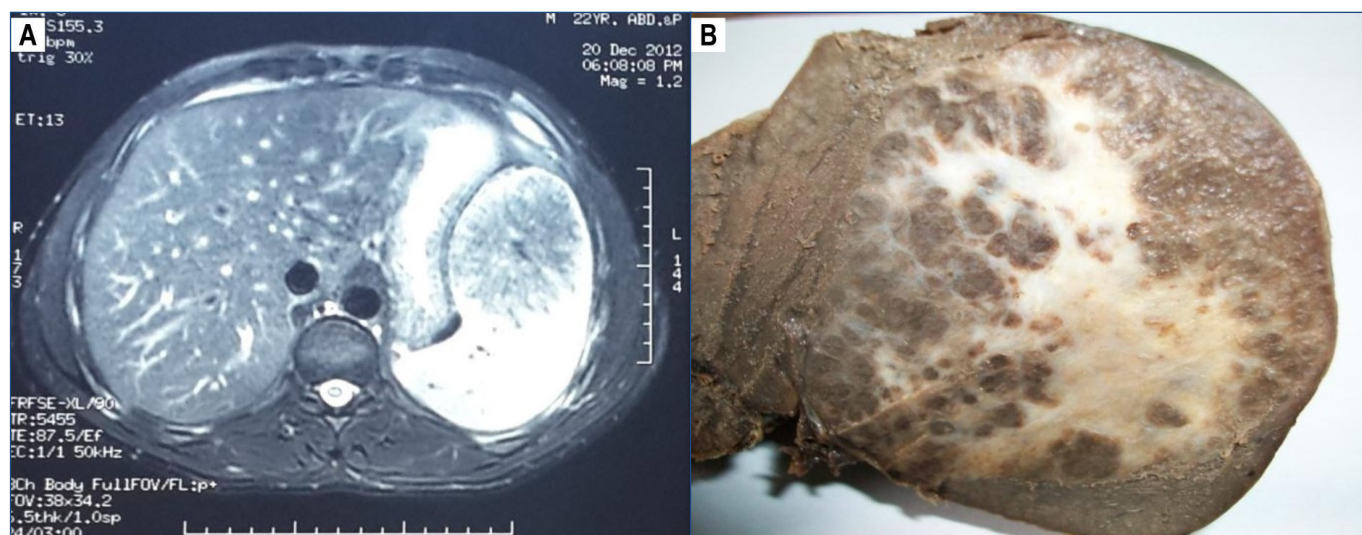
(A) Contrast-enhanced magnetic resonance imaging demonstrating a solitary mass in the spleen, with spoke-wheel pattern of enhancement. (B) Spleen showing a round, well-circumscribed unencapsulated lesion. The cut surface shows multiple dark red nodules separated by stellate-shaped gray-white fibrous bands.
